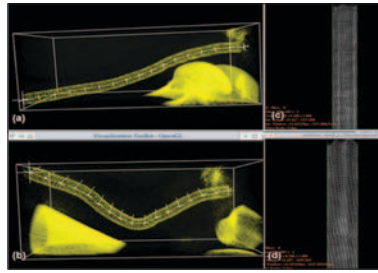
C-arm CT in vivo images of a stent in the a) 'straight' and b) 'bent' positions. The automatically determined centerline is shown, along with the bounding box. The corresponding 2D 'unwrapped' images are shown in c) 'straight' and d) 'bent', and the local shear resulting from the change in position can be seen.
